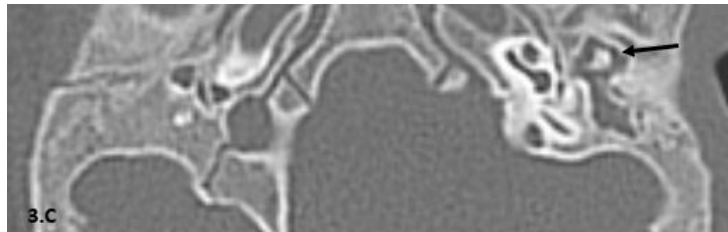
C: Axial CT view, bone window revealed improper alignment of the ossicular chain (black arrow).
